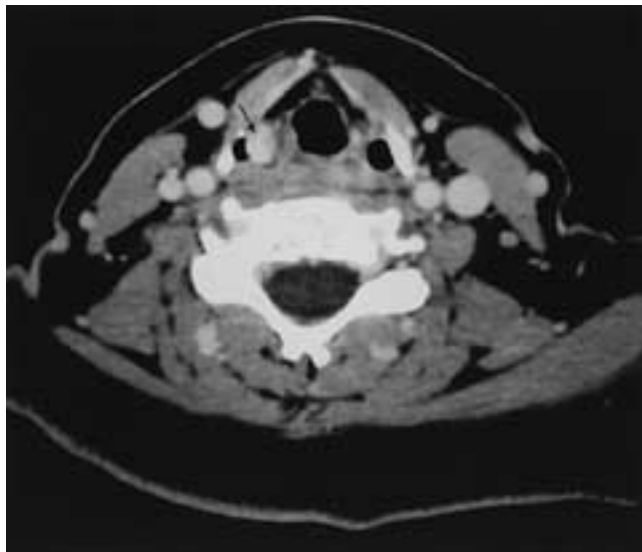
Axial CT of a hemangioma of the pyriform sinus shows enhancement of the small lesion attached to the medial wall of the pyriform sinus just below the aryepiglottic fold. *Arrow*, Tumor.
